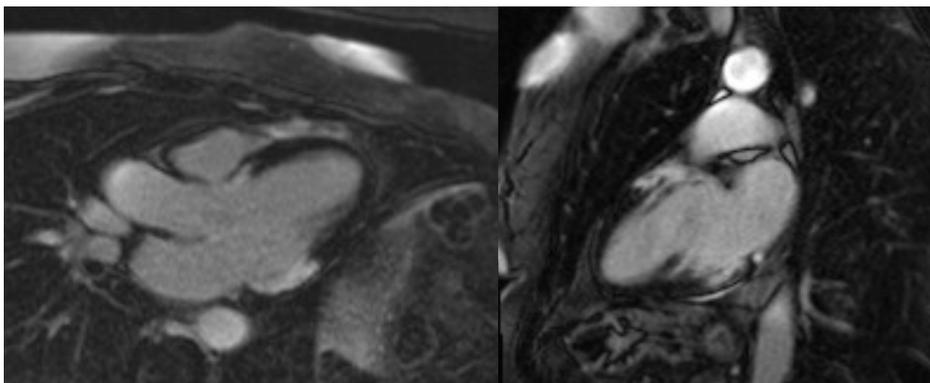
Cardiac magnetic resonance imaging – subepicardial late gadolinium enhancement in the inferior and inferolateral basal segments, and anteroseptal and anterior basal and middle segments.
